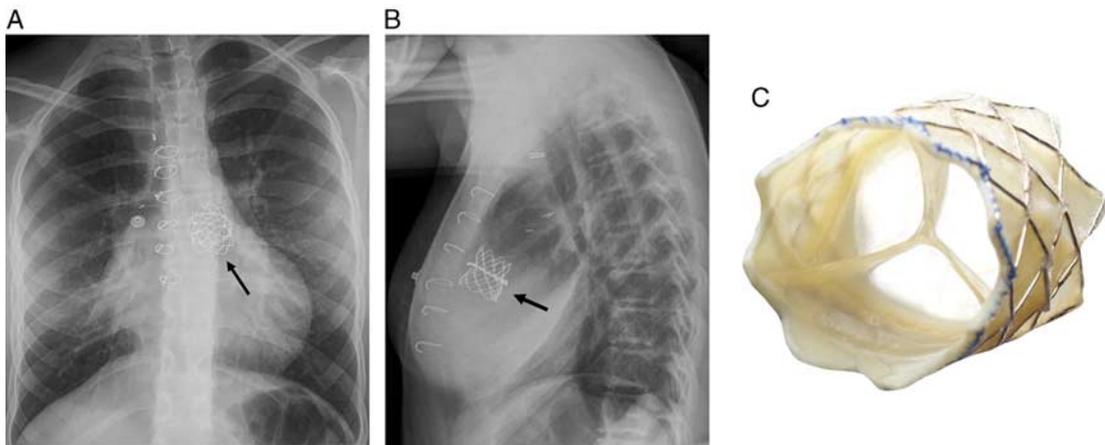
Tetralogy of Fallot after pulmonic valve repair with transcatheter Melody valve: frontal (A) and lateral (B) radiograph of patient with history of repaired tetralogy of Fallot with right ventricular outflow tract-PA conduit after Melody valve (black arrow) placement in the pulmonic position. Melody valve (used with permission) (C). full color online
